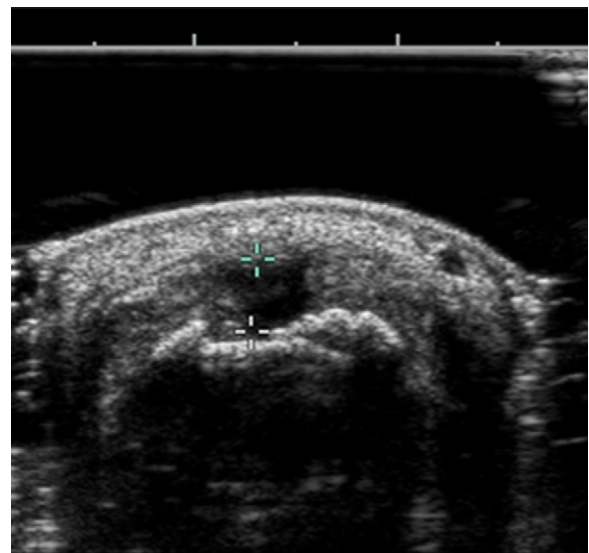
A representative dorsal axial high-frequency ultrasound image assessing the articular capsule distension in depth of a proximal interphalangeal (PIP) 3 joint of a 54-years old female patient with OA.
